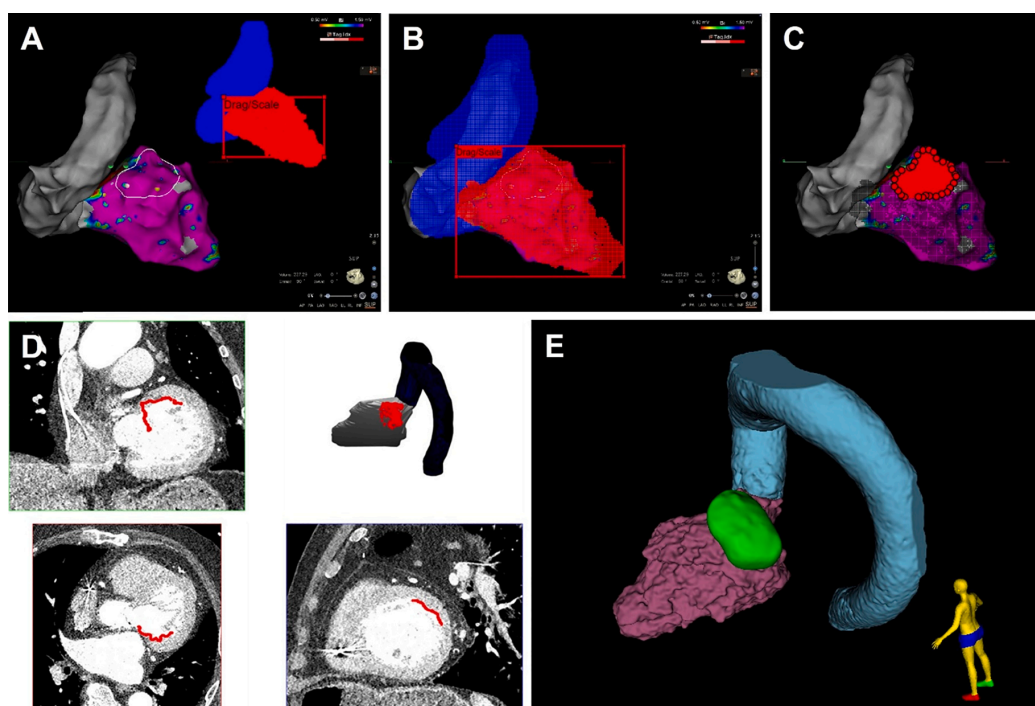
Representative case of 2D-3D registration followed by target creation using CARDIO-RT and 3D Slicer softwares. (A) CARTO 3 electroanatomical mapping (EAM) screenshot and the computed tomography (CT) point clouds of left ventricle (LV) blood pool (red) and aorta (blue) used as additional registration reference before registration. The EAM screenshot and CT-based point clouds are both visualized from superior view, and the white shape in the EAM screenshot is the predefined ventricular tachycardia (VT) target. (B) Registered EAM screenshot and CT contours. (C) Target points on the LV blood pool defined by delineated polygon along the intended target. (D) Registered VT target (red) on the cardiac CT slices and 3D view of the LV, aorta and VT target. (E) Transmural cardiac clinical target volume (green) according to the 2D-3D output.
